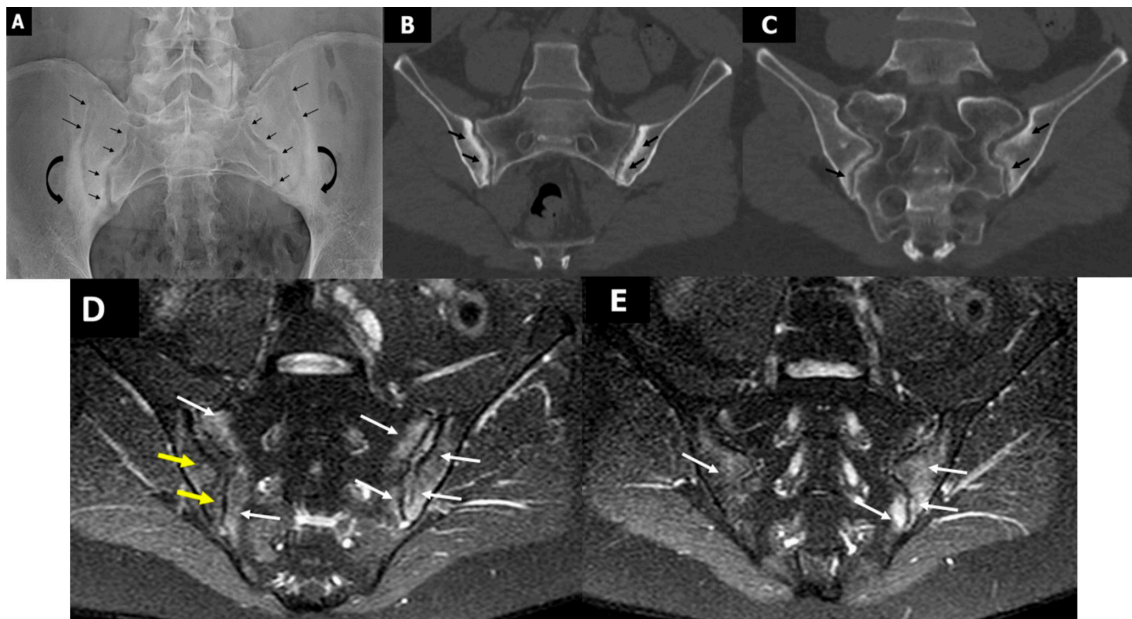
A: Radiograph of the SIJs shows four SIJs (arrows): para-articular sclerosis on both iliac sides with evidence of ankyloses mostly on the external (curved arrows). B: CT. Four SIJs external and (C) internal: Para-articular sclerosis of the SIJs ilium side, shown as hyperdense signal (arrows). D: MRI. Oblique transversal STIR images of the four SIJs external and (E) internal: Para-articular bone marrow oedema, shown as hyperintense signal on STIR (arrows) and para-articular sclerosis of the SIJs ilium side, shown as hypointense signal (yellow arrows).
